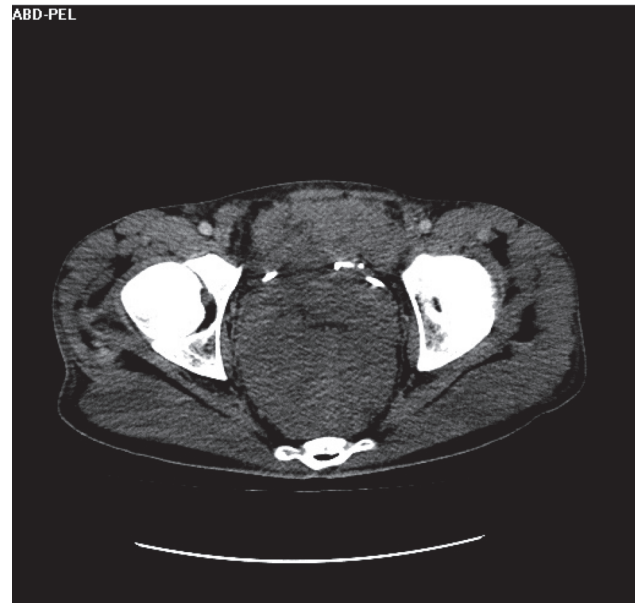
Computed tomography scan (CT scan) shows retroperitoneal soft tissue mass behind the bladder compressing the rectum and displacing the adjacent organs.
